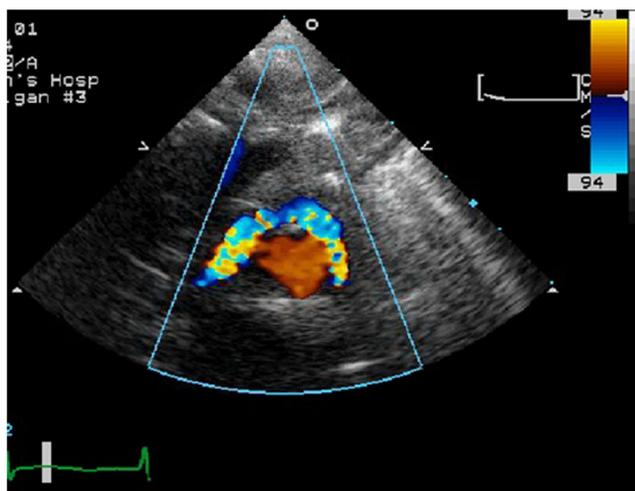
A 21-year-old male with D-TGA status post arterial switch surgery. High parasternal view showing typical pulmonary artery branches straddling anterior/superior to the aorta due to the LeCompte maneuver (branch pulmonary arteries pulled anteriorly) with flow acceleration
